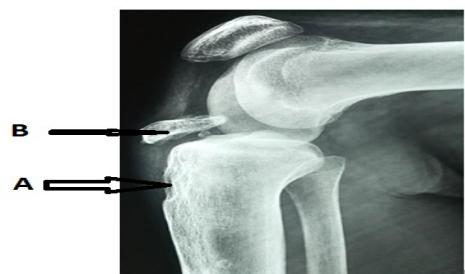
X-Ray of the affected knee at presentation showing area of avulsed tuberosity (B) and its empty bed (A)
